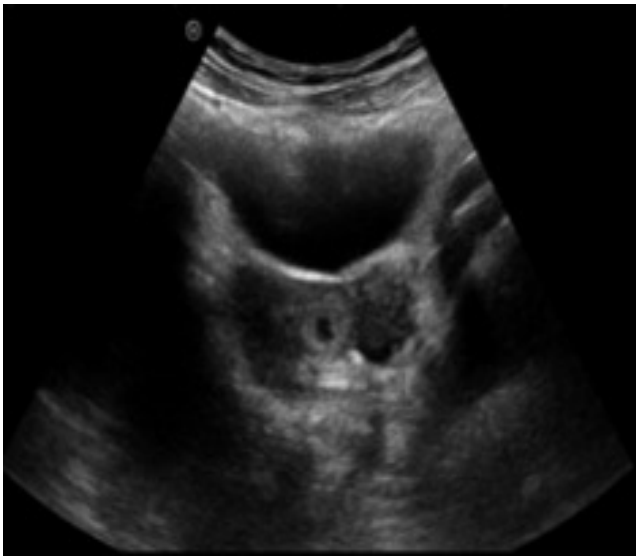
Ultrasound images showing left interstitial pregnancy, measuring around 15 × 16 mm.
